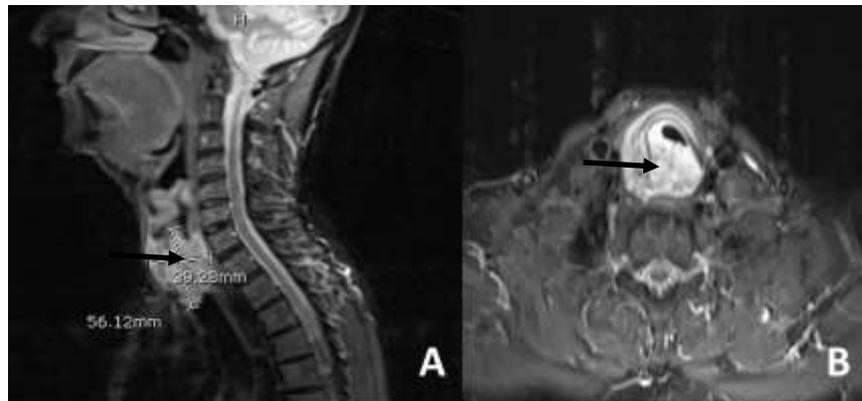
MRI neck showing soft tissue mass involving subglottic trachea (Post coring) with both intraluminal and extraluminal component in A) sagittal and B) axial section
